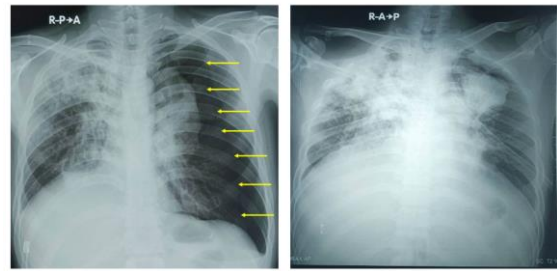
Chest X-ray on first day of admission (a) and chest X-ray on sixth day of hospitalization (b) (yellow narrow showed pneumothorax).
